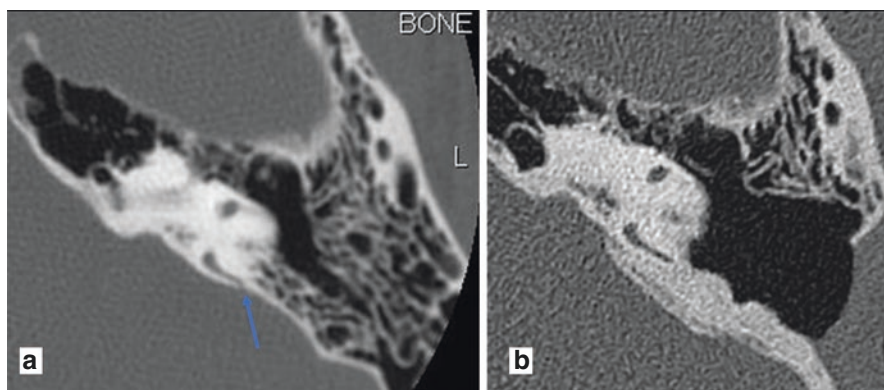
Preop (a) and postop (b) CT scan of PSCD repair using calvarial bone and HA cement. Arrow points to PSCD, dehiscent toward posterior fossa dura
